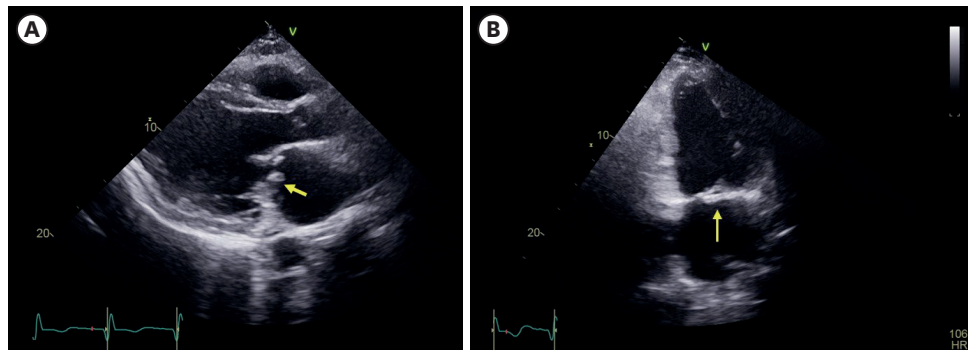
Transthoracic echocardiography. Parasternal long axis view (A) and apical 2 chamber view (B) of the transthoracic echocardiography showed linear shaped mass (yellow arrow) originated from posterior mitral annulus with severe mitral regurgitation.
